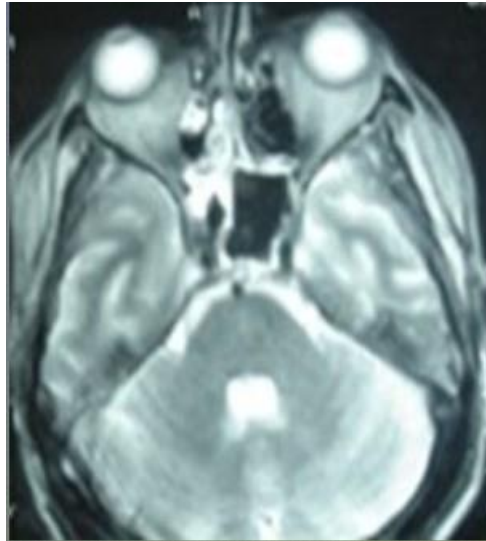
Axial MRI of the orbit, paranasal sinuses, and brain showing involvement of medial orbit and abnormal fat intensity along with involvement of ethmoid sinus (LE)
